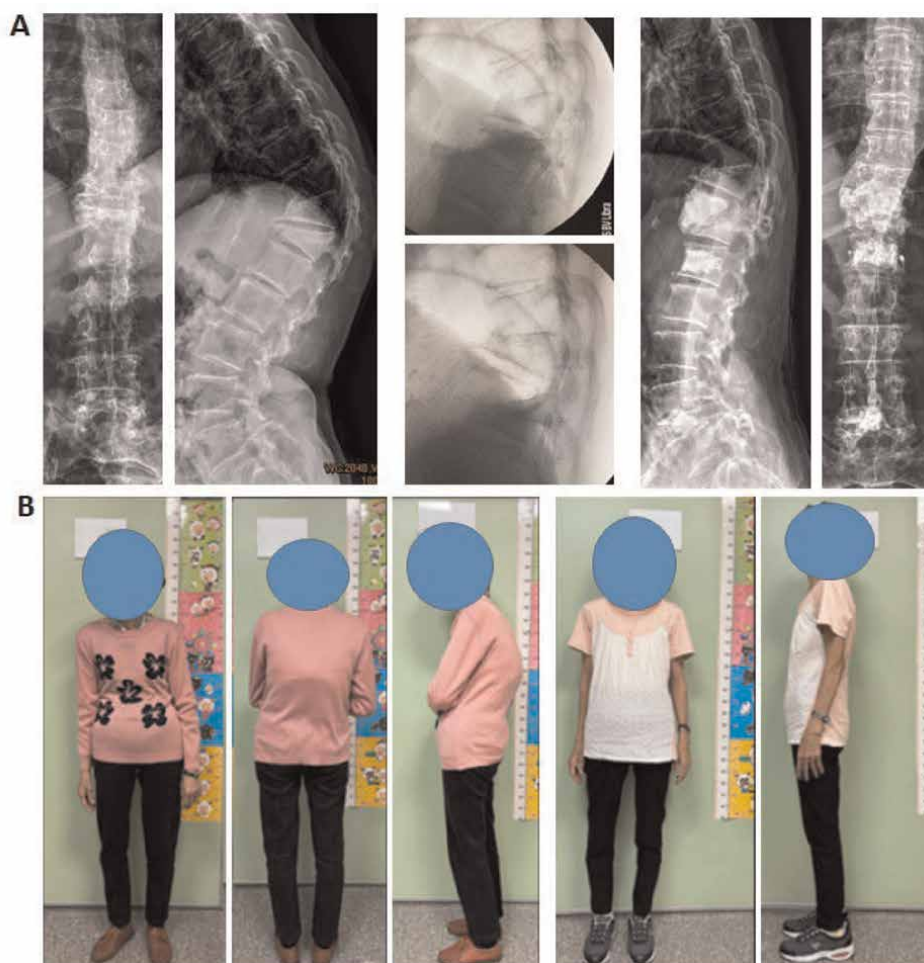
Demonstrated radiographs of (A) and corresponding pictures (B) of a 78-year-old female with T10-L1 kyphosis, T10-L1 lateral Cobb's angle pre-op: 78°; postural reduction: 77°; post-manual reduction: 34°; post-vertebroplasty 33°. T12 open-wedge reduction was noted. T12 and T11 vertebroplasties were done.
